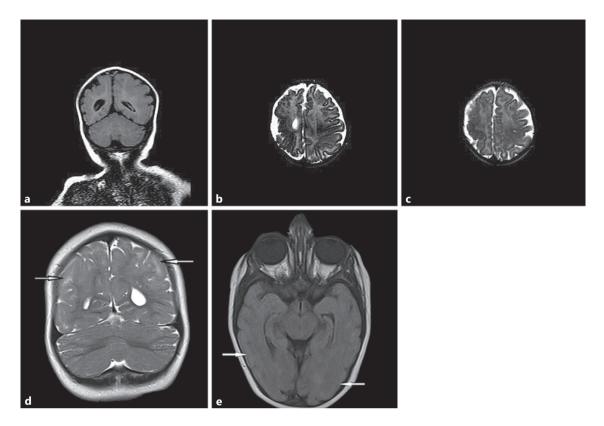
Radiological findings. Patient 1: a Symmetrical mild ventriculomegaly, simplified gyral pattern, and cortical dysplasia located in the right temporaparietal lobe on T2 FLAIR coronal image. b, c T2-weighted axial images of brain. Patient 2: d Pachgyria pattern of cortical thickness on coronal T2-weighted image. e Axial FLAIR image.
